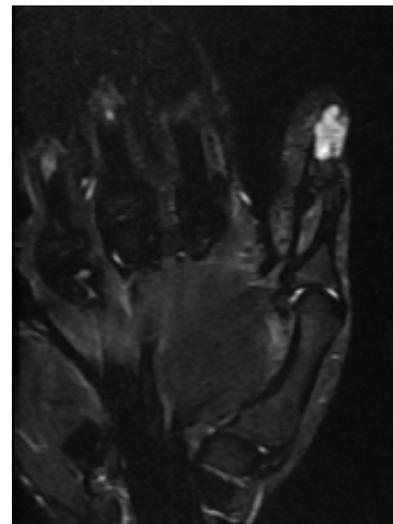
Coronal T1 MRI image.
